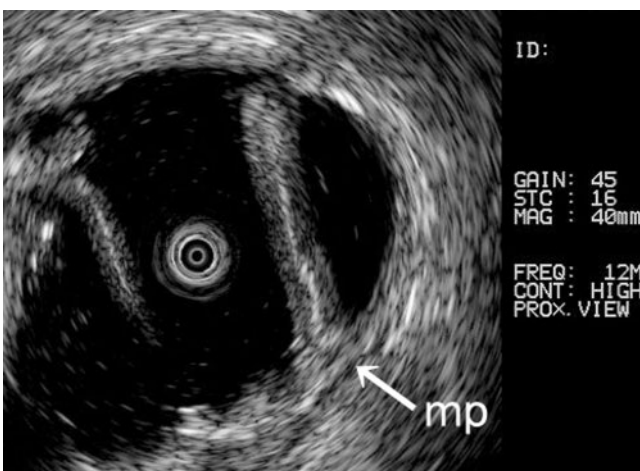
Patient 7. Endoscopic ultrasound shows an elongated polypoid lesion consisting of intact first to third layers, revealing mucosal and submucosal colonic layers. There is no echogenic mass or muscularis propria (arrow-mp) layer in the polyp.
